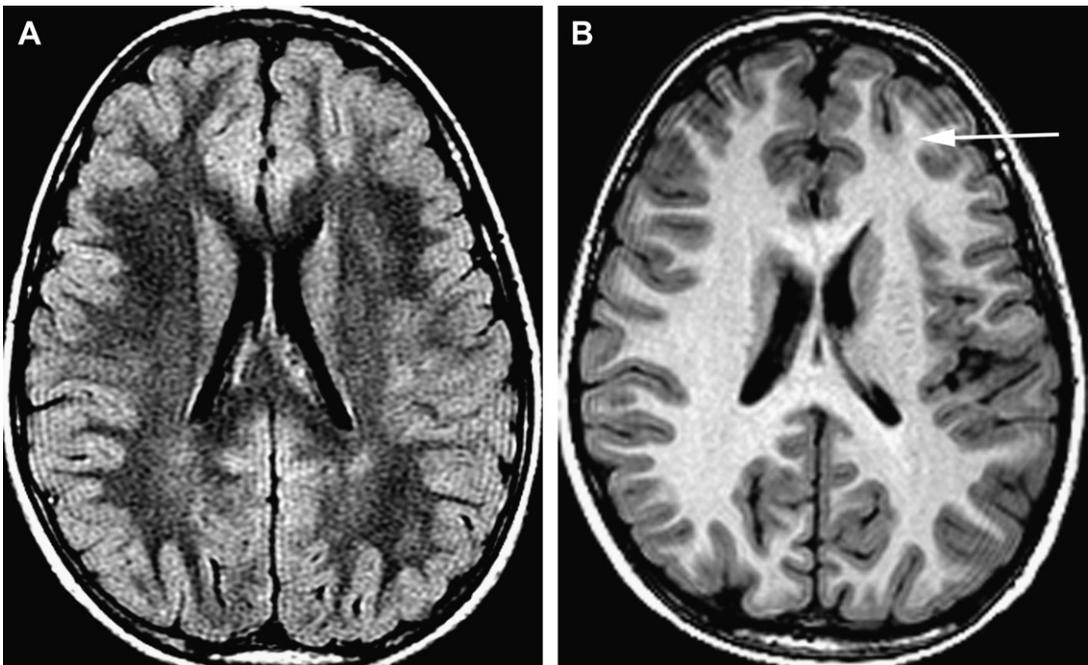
Bottom-of-the-sulcus FCD II. (A) Axial FLAIR. The image is essentially unremarkable except that the superior frontal sulcus on the left side appears to be deeper than on the right side. (B) Thin T1 imaging demonstrates a bright T1 signal of the cortex in the bottom of this abnormal sulcus (arrow); this is highly suggestive of FCD II.
